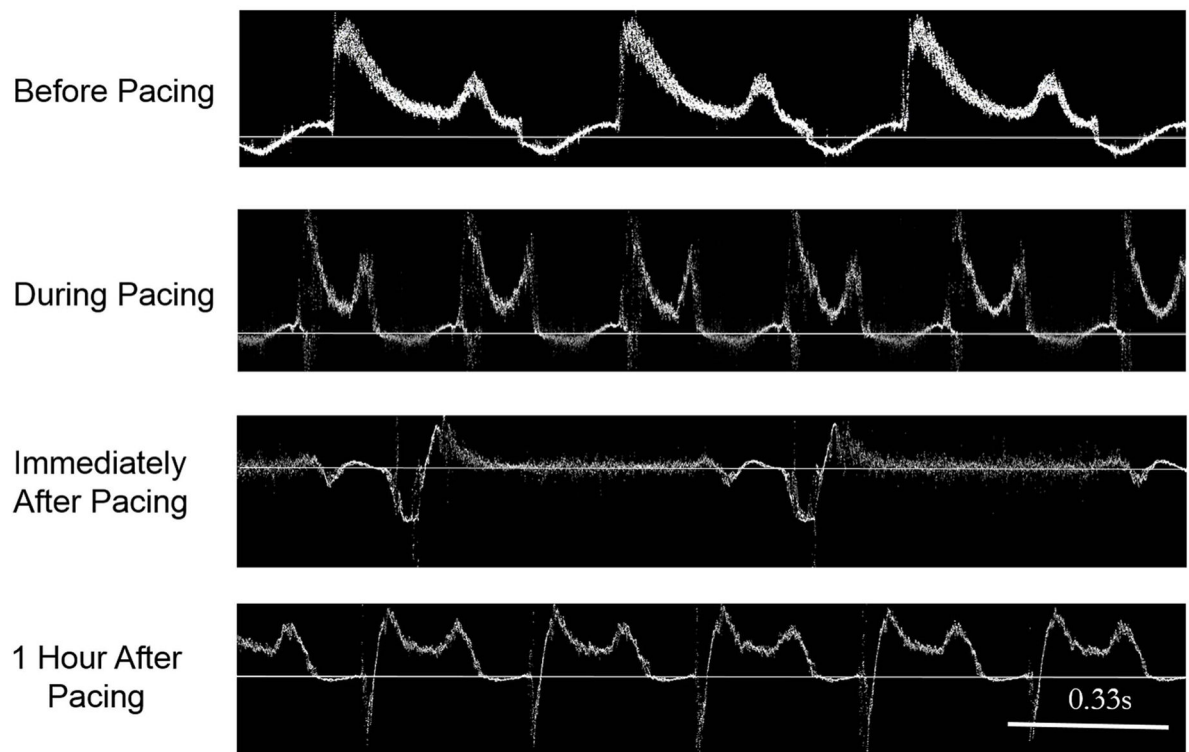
Pulsed Doppler OCT tracings from the inflow tract of the 2-day (stage 14) embryonic quail heart before, during, immediately after, and 1 hour after optical pacing (OP). Deflection above the solid line indicates forward flow, while deflection below denotes regurgitant flow.
